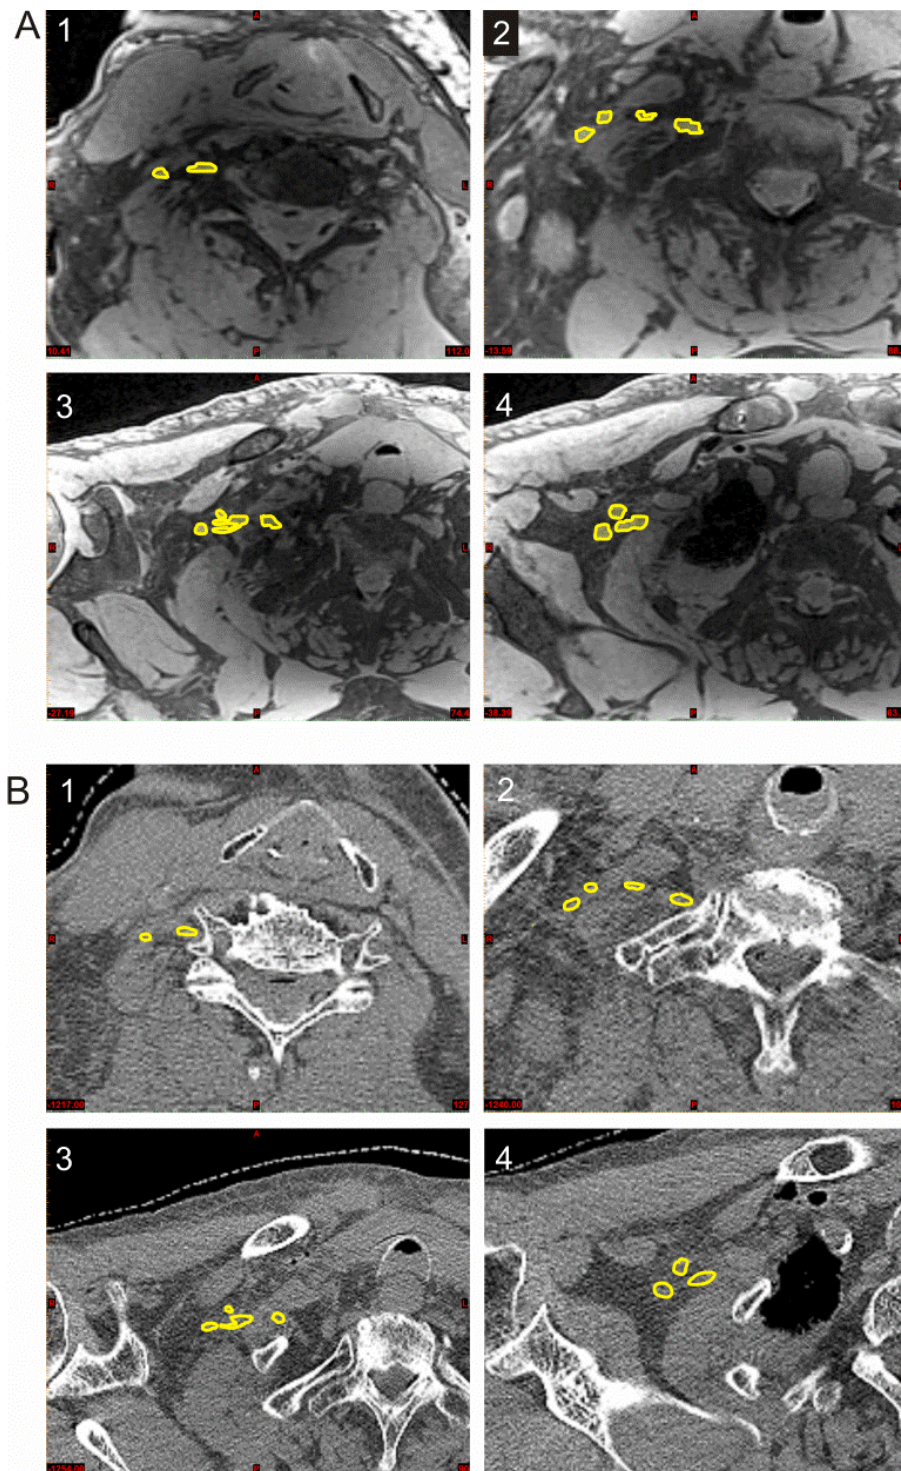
The anatomically validated BP contours on MRI (A) and CT (B) in four different BP regions (1-4).
